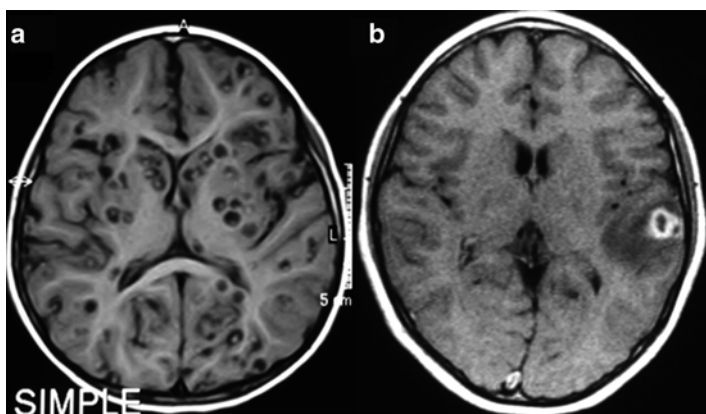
MRI of parenchymal neurocysticercosis. (a) Viable cysts showing the scolex. (b) Colloidal cyst appearing as a ring-enhancing lesion with perilesional edema
